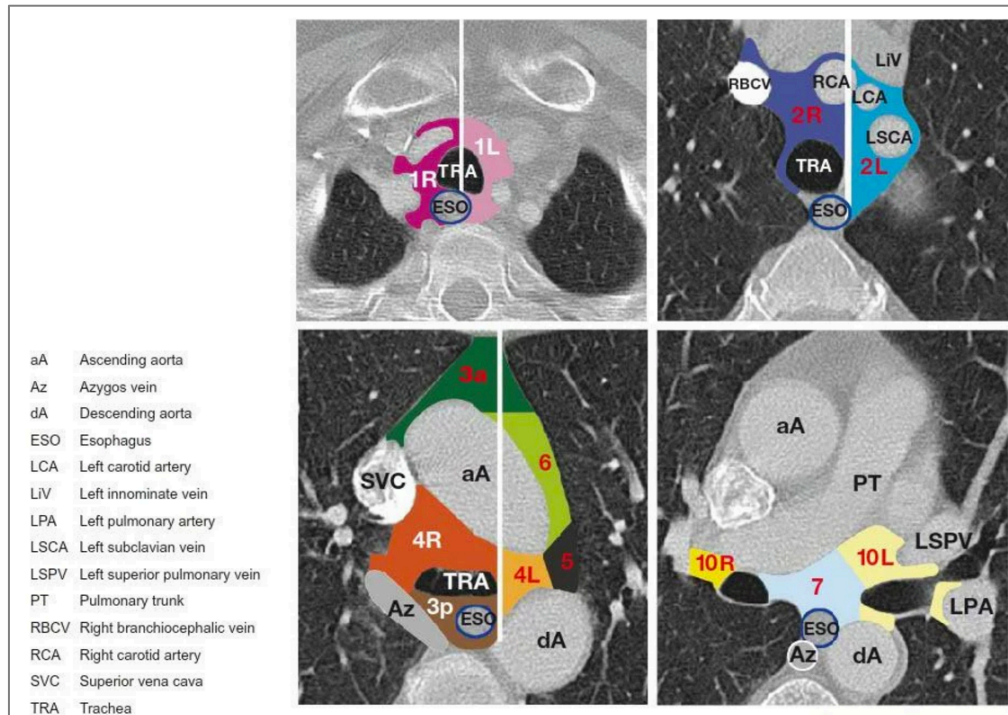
Olympus CT scan lymph node mapping for TNM staging (Abramyuk et al., 2012). aA: Ascending aorta, Az: Azygos vein, dA: descending aorta, ESO: esophagus, LCA: left carotid artery, LiV: left innominate vein, left pulmonary artery, LSCA: left subclavian vein, LSPV: left superior pulmonary vein, PT: pulmonary trunk, RBCV: right bronchocephalic vein, RCA: right carotid artery, superior vena cava, TRA: trachea.
